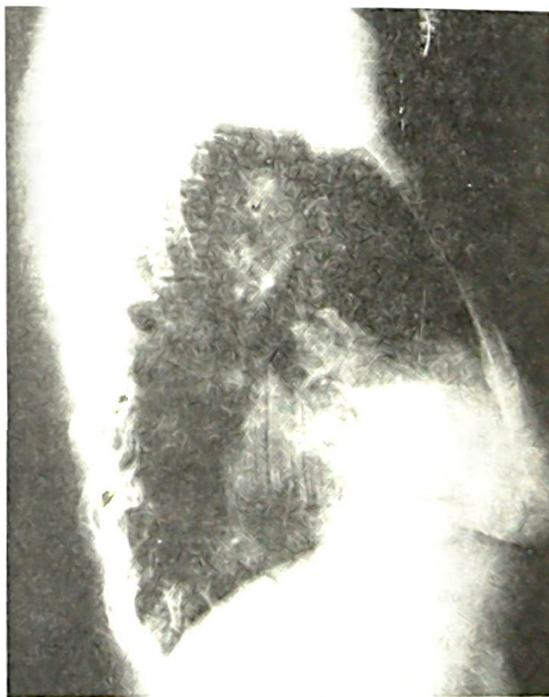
(a & b): Chest Radiograph on Case 2 (PA & Lateral) showing widened mediastinum, right aortic arch (A), bulky left hilum and a rounded retro-tracheal soft tissue mass (M). Note cardiomegaly.
